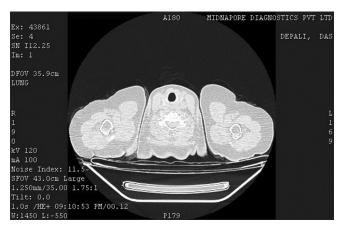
CT findings with D-Dimer <1.4
